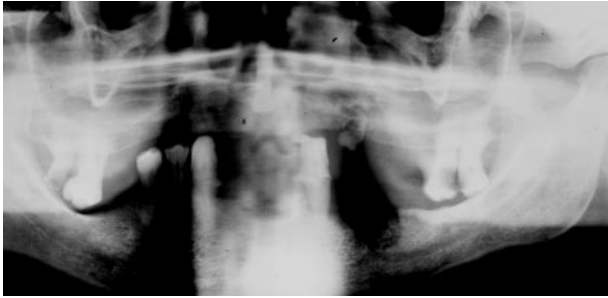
Case 2: Panoramic radiograph showing tumour invasion in the left premolar region
